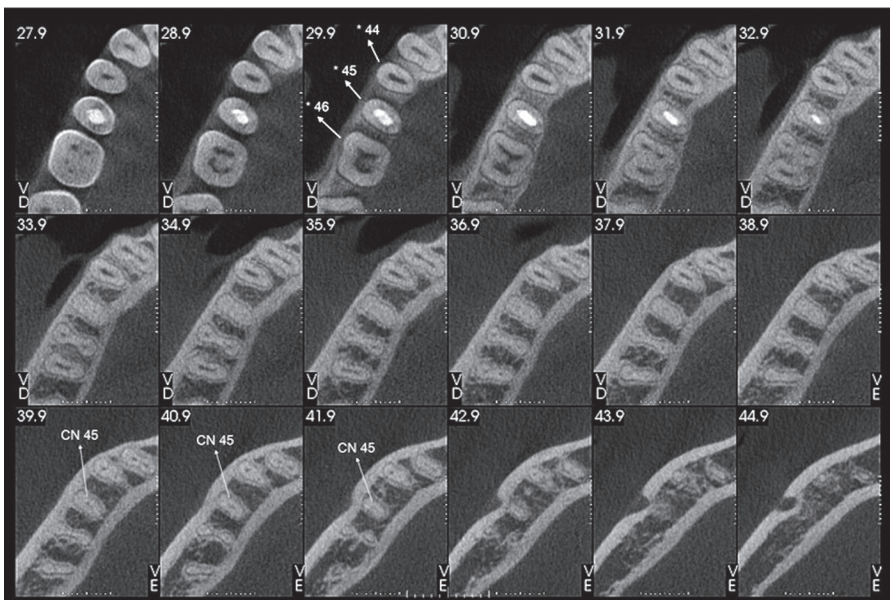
Axial cross sections of cone beam computed tomography in the 54-month follow up.
